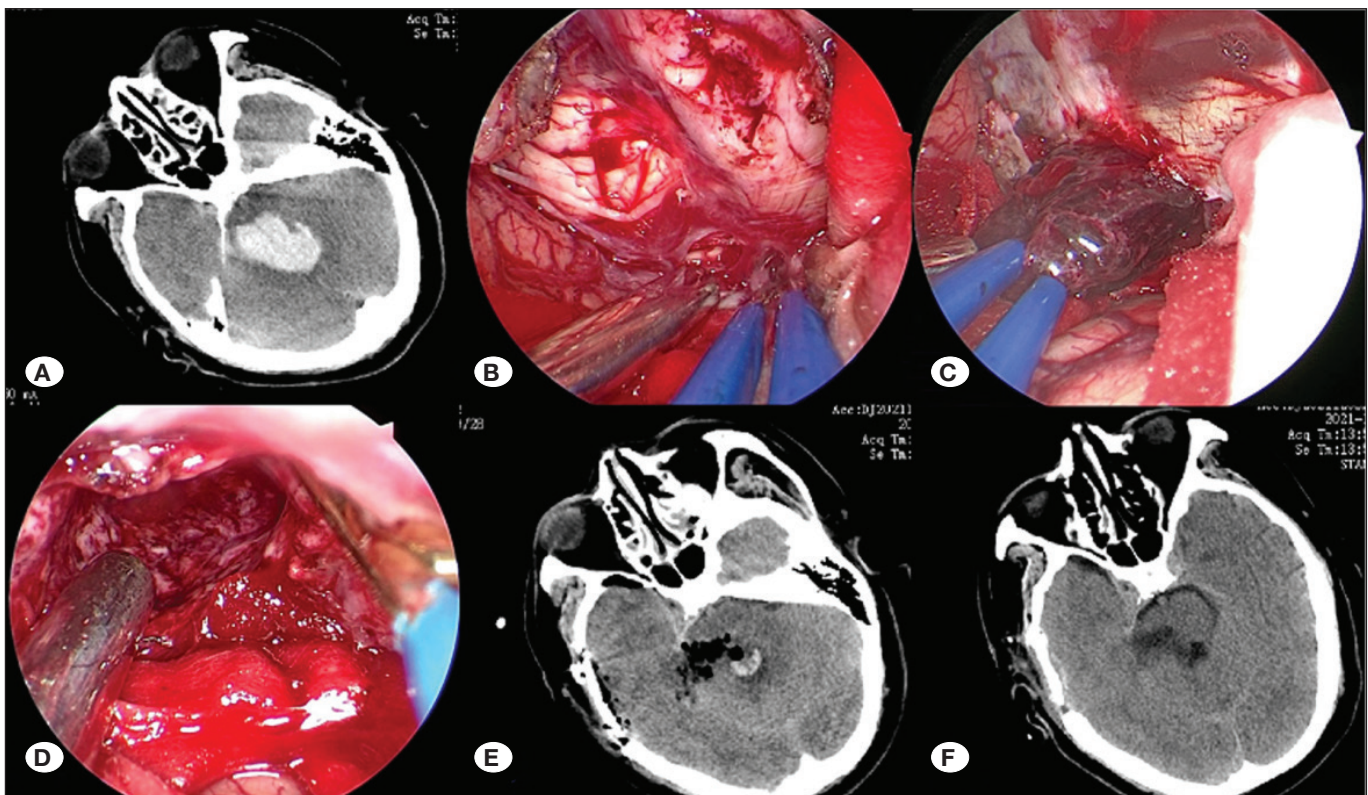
Preoperative head computed tomography (CT) showing that the largest level of the hematoma was located in the right pontine region (A). The tentorium of the cerebellum was cut and the brainstem structure was exposed (B). The hematoma was removed by neuroendoscopy (C). Examination of the hematoma cavity showed no obvious active bleeding (D). CT examination of the head within 24 hours revealed satisfactory brainstem hematoma clearance after surgery (E). CT examination of the head one month after surgery (F).
